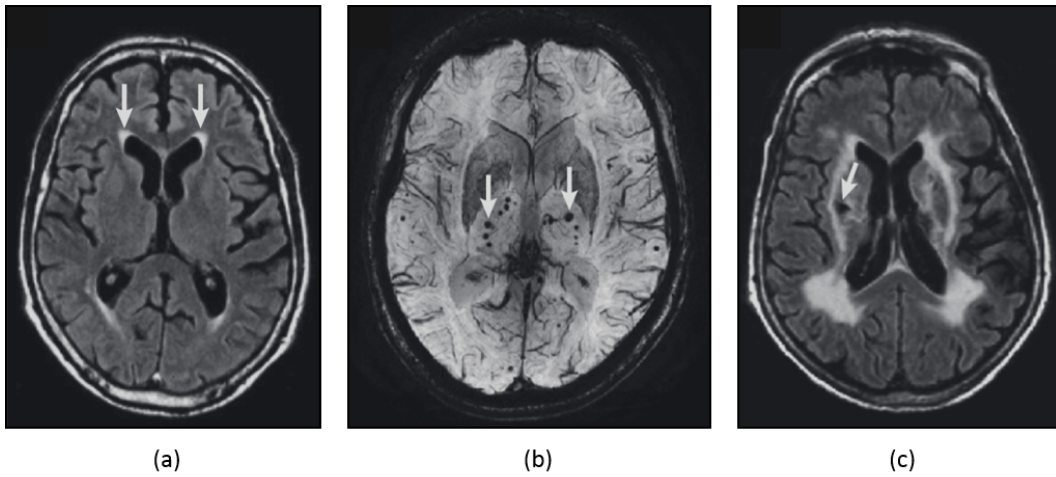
Lesions characteristic of cerebral SVD. (a) Axial image with periventricular WM hyperintense lesions on FLAIR MRI; (b) Axial T2*-weighted image showing microbleeds as rounded hypointensities in the basal ganglia (white arrows) and the cortex; (c) An axial FLAIR image showing a lacunar infarct in the deep WM and GM (white arrow; images taken from [36]).
